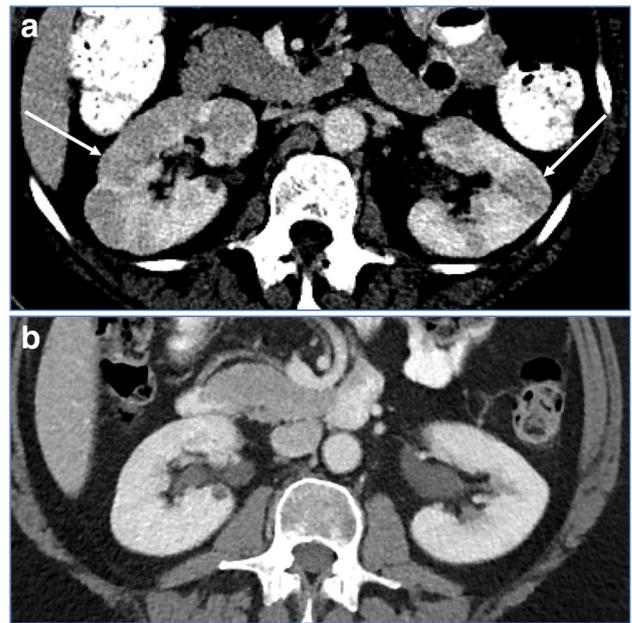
IgG4 related disease affecting the kidneys in a 50-year-old woman. a Post-contrast axial CT demonstrates lobulated kidneys with innumerable hypoenhancing nodules throughout the cortex (arrow). b Three-month follow-up contrast-enhanced CT demonstrated resolution of the renal nodules after treatment with steroids
